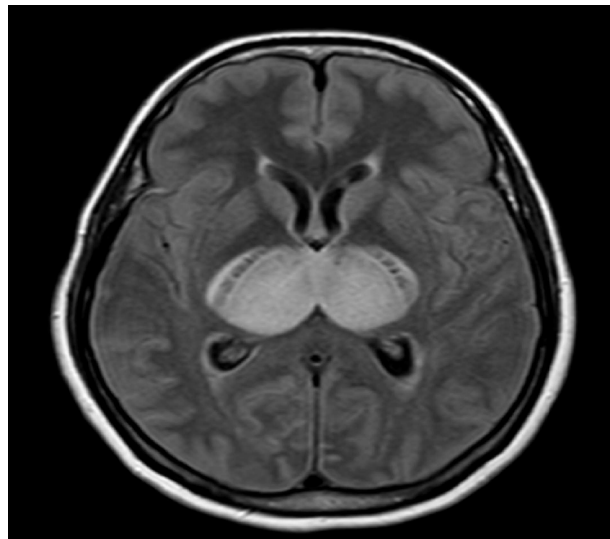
Axial FLAIR MRI showing bilateral thalamic hyperintensities part of the characteristic "doughnut in the brain" appearance
